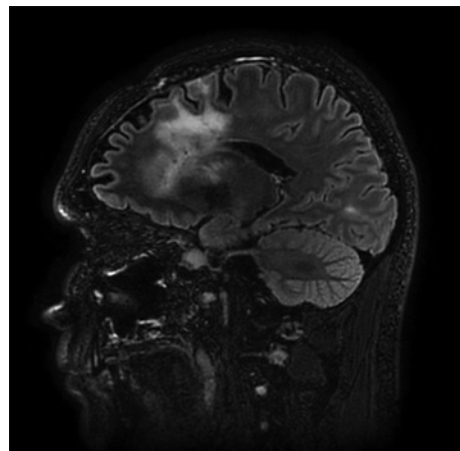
July 2020 MRI sagittal 3DFLAIR, before starting regorafenib treatment.
